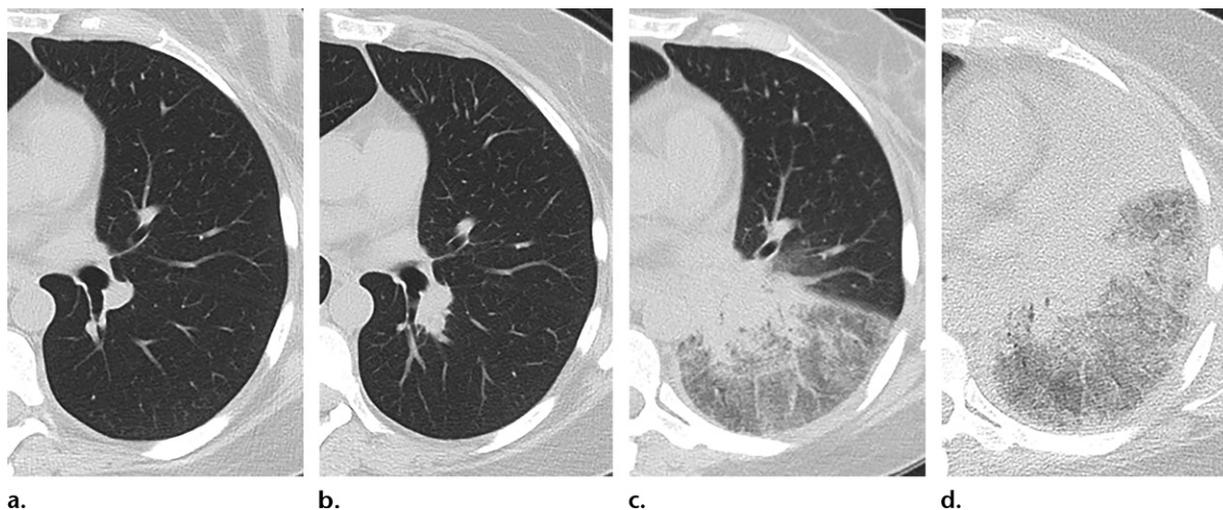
Rapid progression of PM in a 41-year-old woman who underwent stem cell transplant for acute myeloid leukemia. (a) Axial CT image of the left lung is clear on day 1. Note the patent superior segmental left lower lobe bronchus. (b) Axial CT image obtained on day 12 shows a new nodule in the left lower lobe abutting the superior segmental bronchus. (c) Axial CT image obtained on day 21 shows increased consolidation and complete lobar ground-glass opacification. The superior segmental bronchus is now occluded. (d) Axial CT image obtained on day 23 shows left upper lobe collapse and continued complete ground-glass opacification of the left lower lobe.
